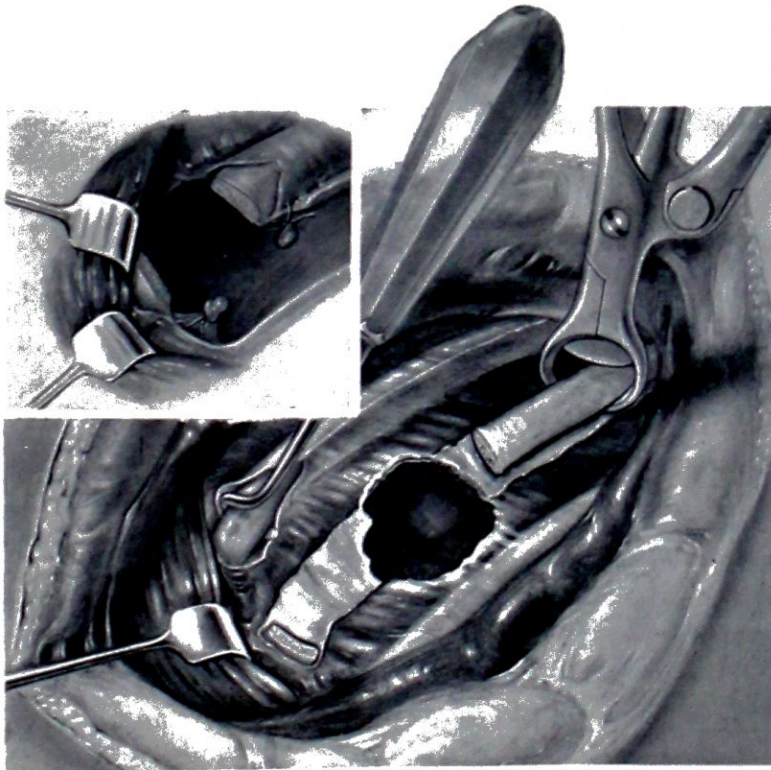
Transthoracic laparotomy. The external wound, including a piece of shattered rib, has been excised. With fresh instruments, more of the rib is removed. The rib above is divided near the posterior end of the wound, in order to allow a good view of the interior by suitable retraction. *Inset*: The rib above divided, and its intercostal vessels ligated.
